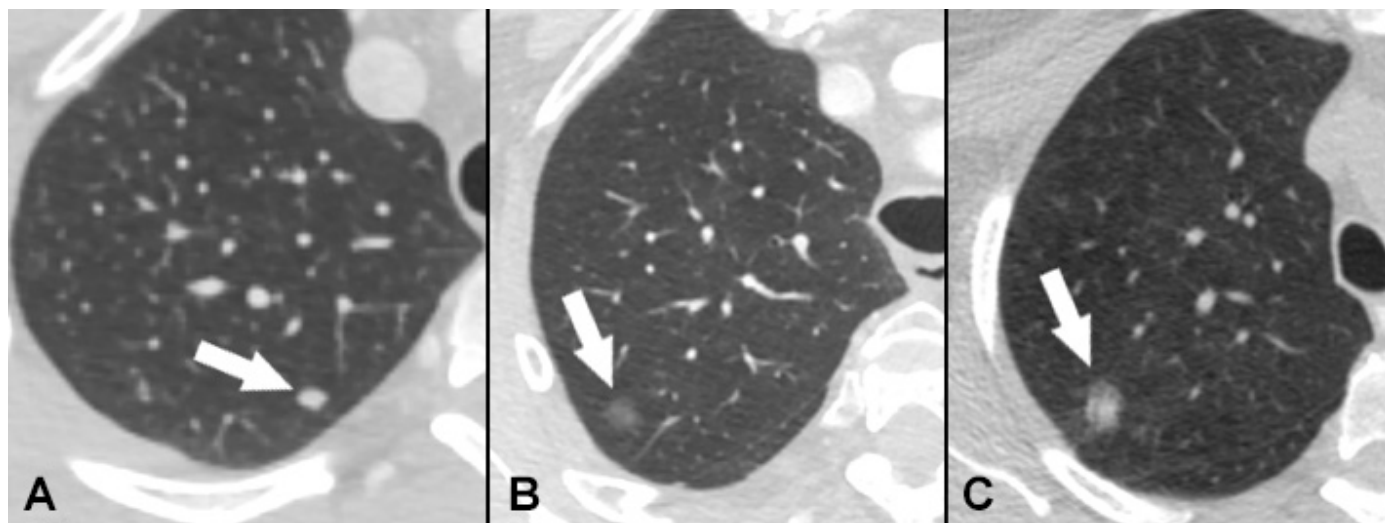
Axial CT images demonstrating solid (A) and subsolid (B, C) pulmonary nodules. Whereas all subsolid pulmonary nodules contain a ground-glass component, some are pure ground glass (B) while other also contain a solid component (C).
